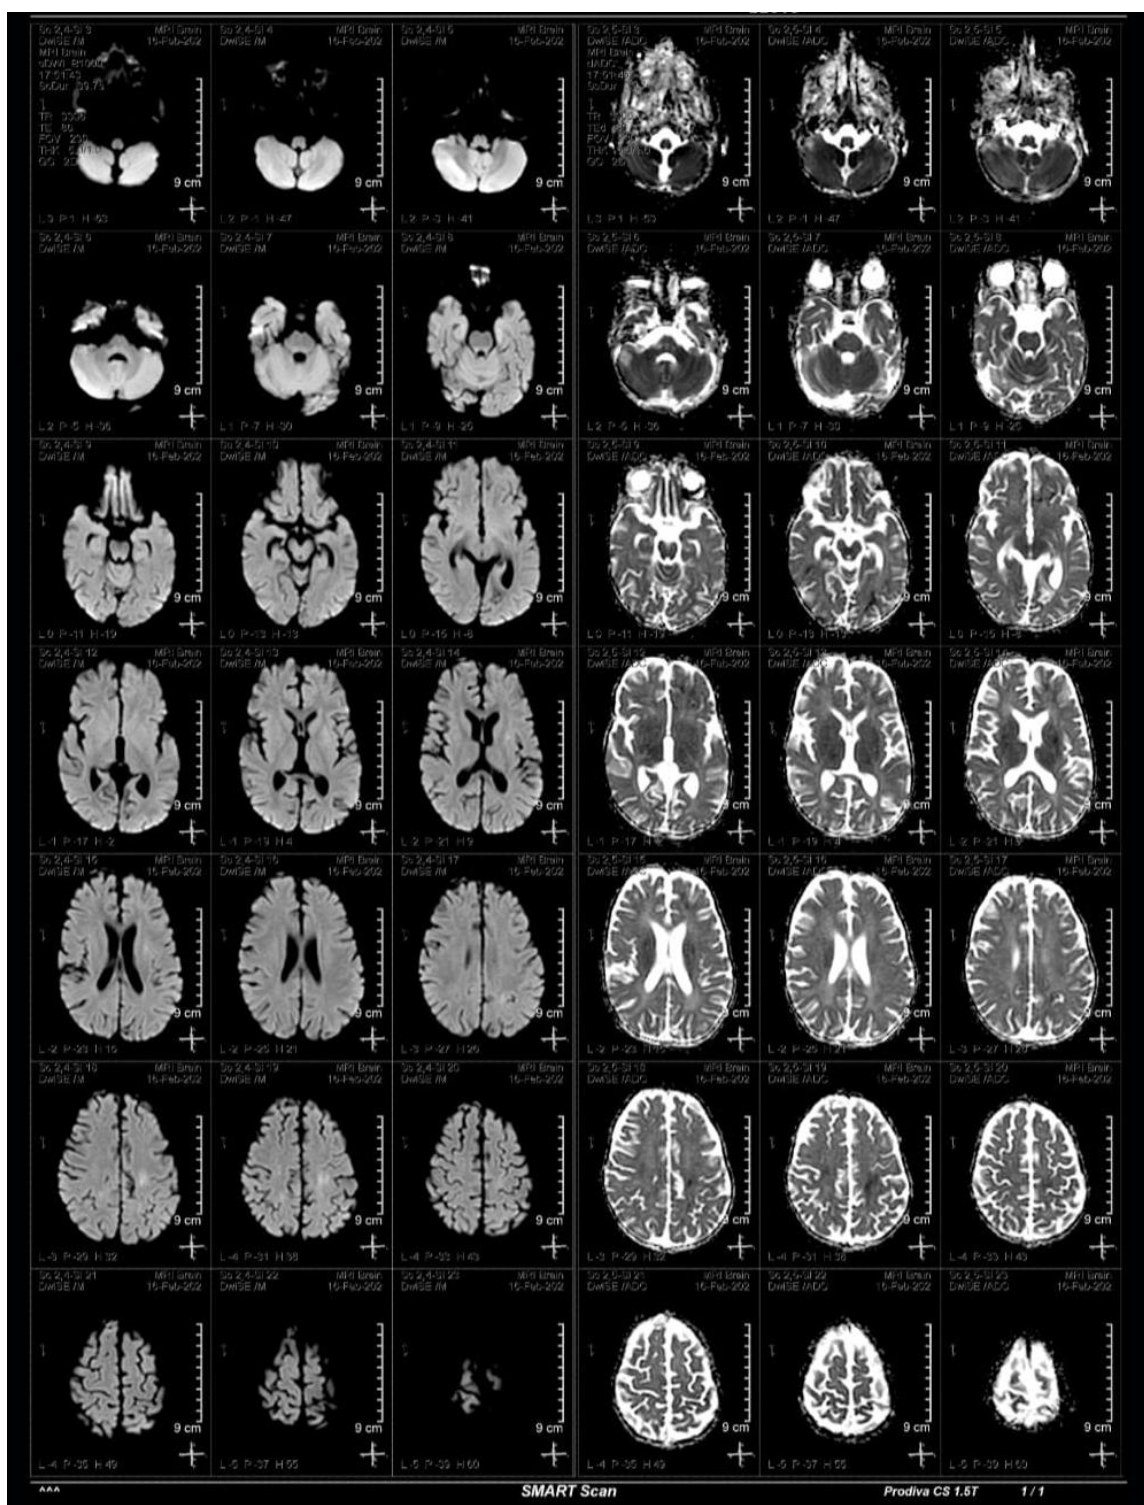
MRI brain showing left-sided infarction
